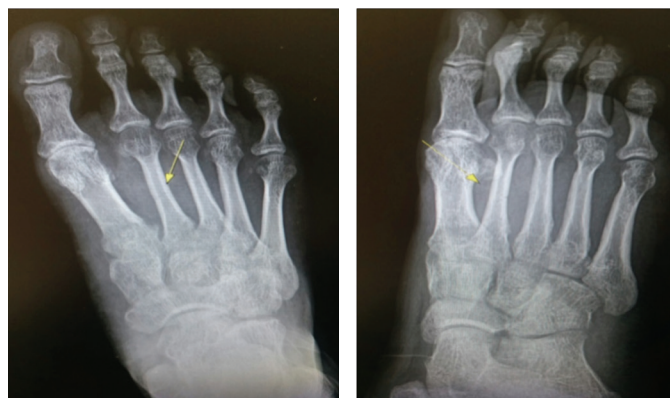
X-ray images taken on May 2, 2017.
